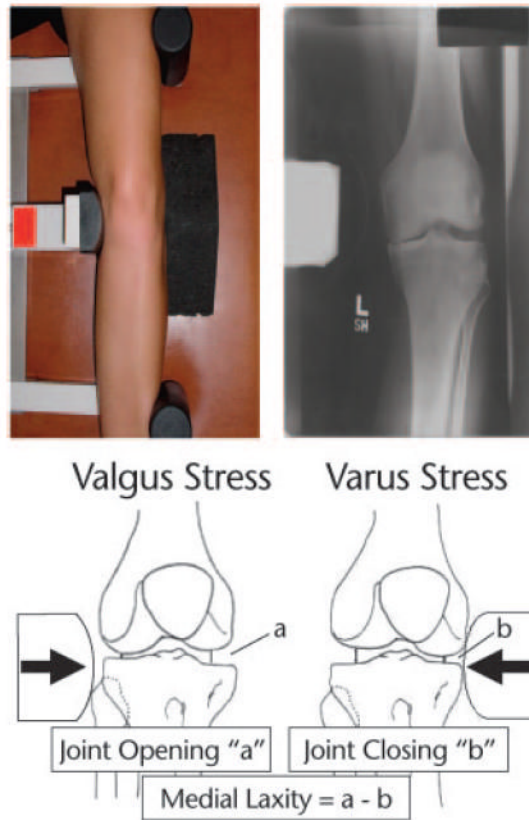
Setup for stress radiographs. The top images show the limb alignment in the TELOS device (top left) and the resulting radiograph (top right), and the method of calculating medial laxity is shown in the lower images. Lateral laxity was calculated similarly but with subtraction of the lateral joint space in valgus from lateral joint space in varus.
